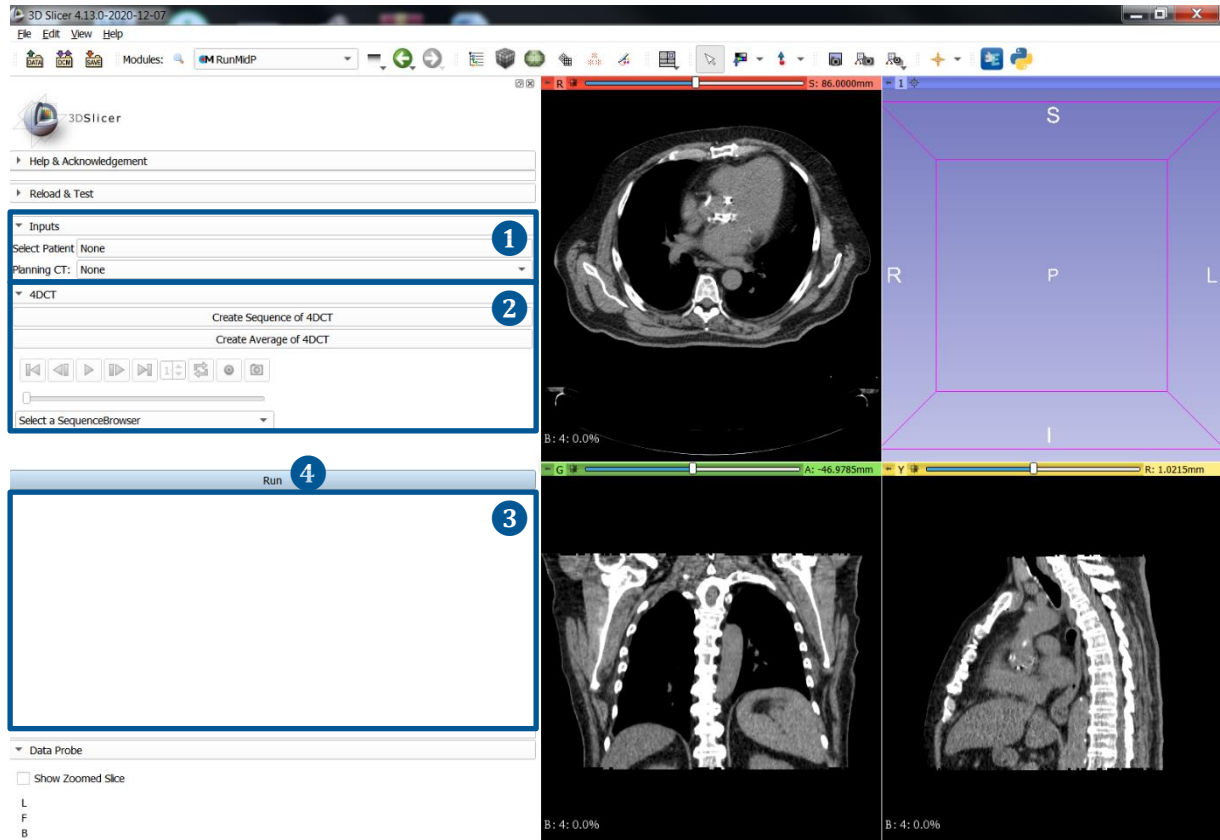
The left side shows the graphical user interface (GUI) of the *RunMidP* module. Four different parts of the module are highlighted: (1) Inputs section, (2) 4DCT section, (3) Log text box and (4) *Run* button. The axial, sagittal and coronal views show the first breathing phase of the 4DCT data (Phase 0%) but can also be used to visualize the Mid-P CT after the module is finished.
